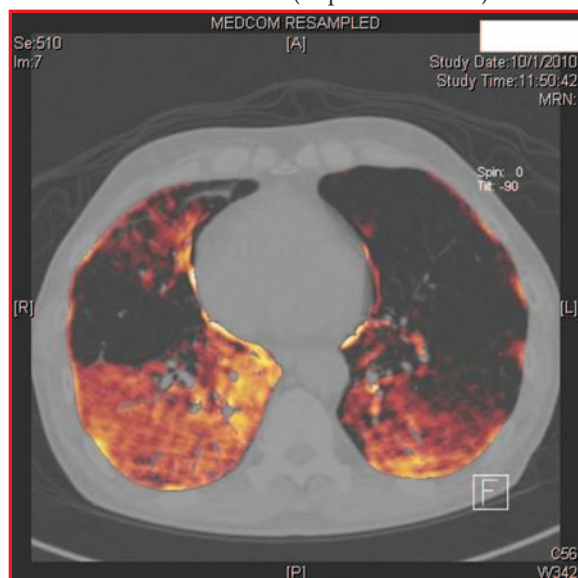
Transaxial section of xenon ventilation CT shows significant decrease in ventilation in right middle lobe and anterolateral basal segment of left lower lobe. (golden is good ventilation and black is poor ventilation)
